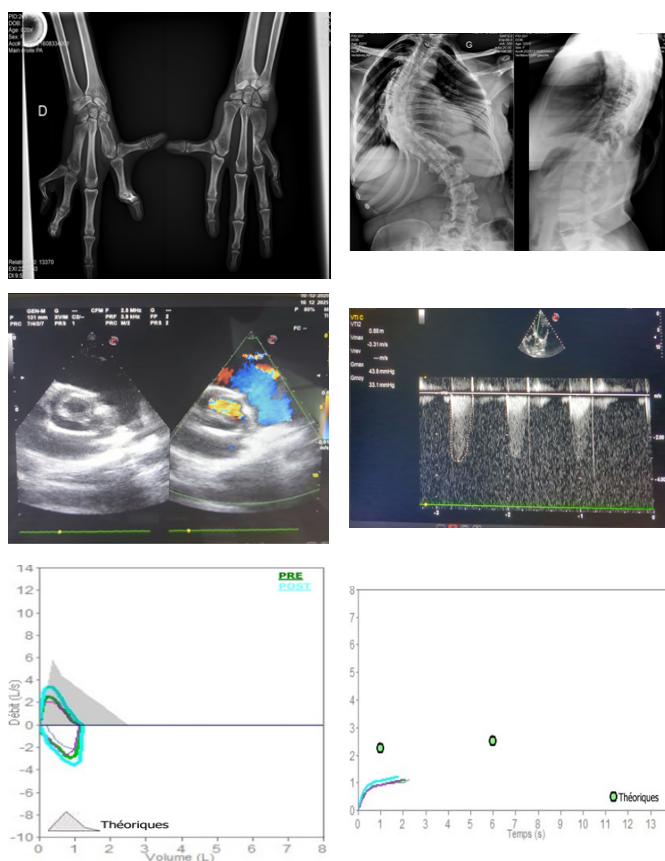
Paraclinical exams : Ectrodactyly at Xray (A) Kyphoscoliosis (B) Bicuspid aortic valve with mild aortic stenosis (C and D) restrictive pattern at the respiratory tests (E and F)
